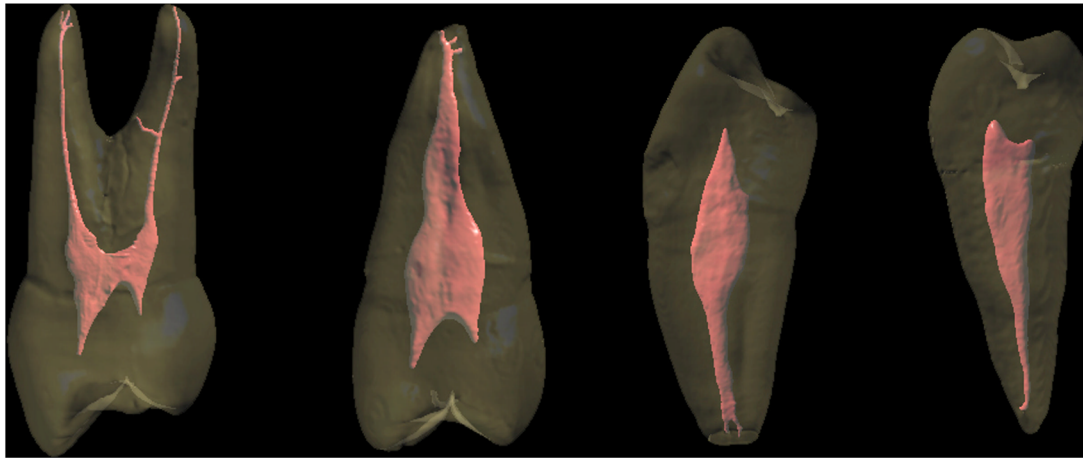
The 4 CT scan images of extracted teeth show the facial prominence of the pulp in the following teeth from left to right: maxillary first premolar, maxillary second premolar, mandibular first premolar, and mandibular second premolar.
